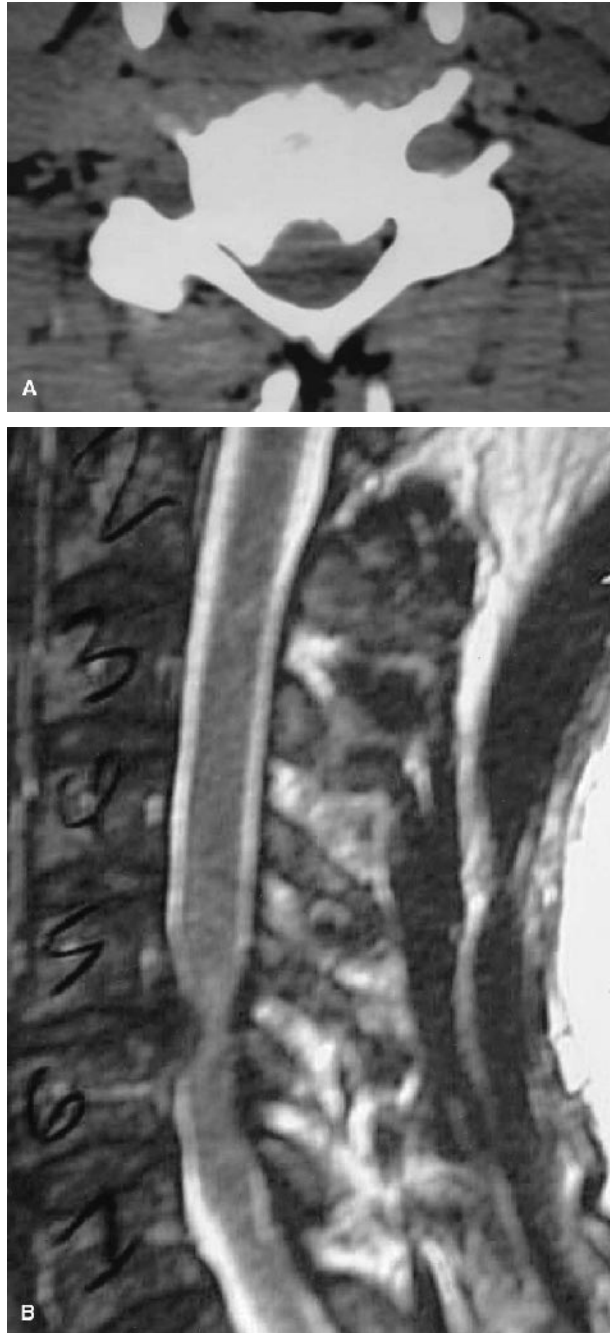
Preoperative axial CT scan (A) and sagittal MR scan (B), both showing spinal cord compression secondary to spondylotic disease. There is high signal in the spinal cord on the MR scan, and compression is primarily secondary to spondylotic osteophytes, best visualized on the CT.
